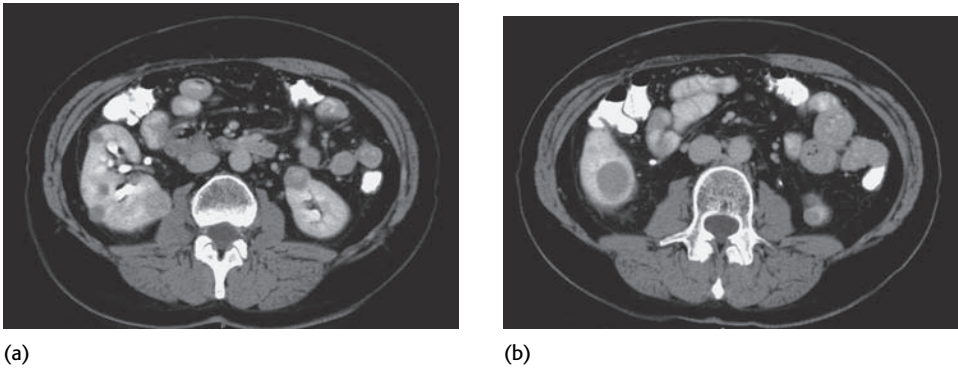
CT Abdomen of a patient diagnosed with Familial Renal Oncocytoma. Multiple bilateral solid tumors are seen (images (a) and (b) are taken from the same series). Prior resection had revealed multiple oncocytomas.
